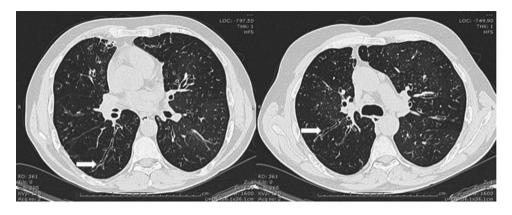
Bronchiectasis in a CVID patient. Panels show bronchiectasis (arrows) in a CVID patient in two different slices of a chest high-resolution CT scan.
